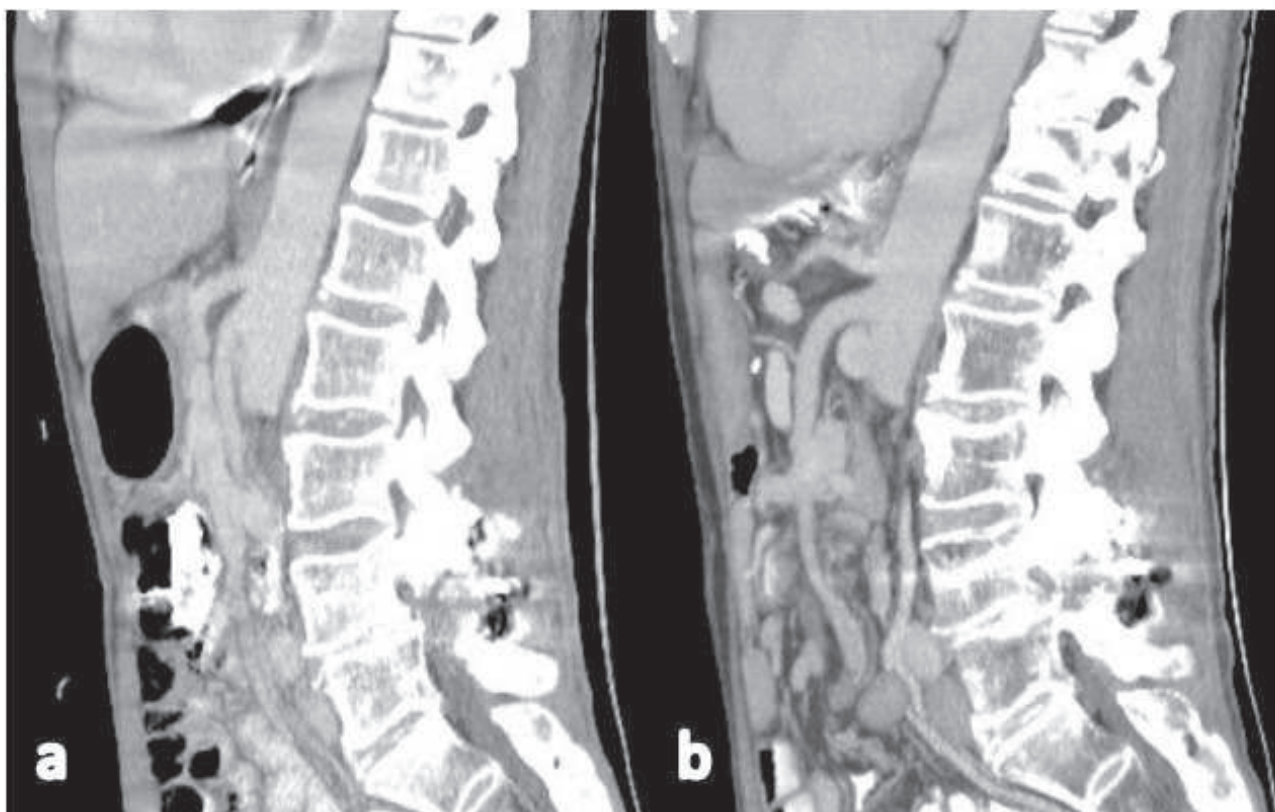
a, b. Sagittal contrast-enhanced abdominal CT images of a 61-year-old male patient taken on different dates. The distal part of the celiac trunk is displaced according to the position of the patient and intraabdominal organs while the angle of the origin is preserved.
